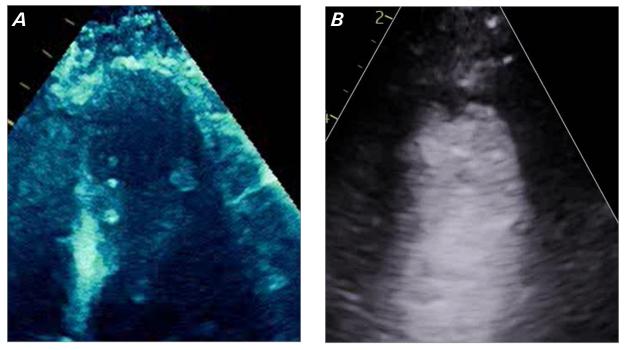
A) Transthoracic echocardiogram shows apical akinesia 20 hours after onset. B) Transthoracic echocardiogram with contrast agent shows complete resolution of akinesia at 44 hours.
